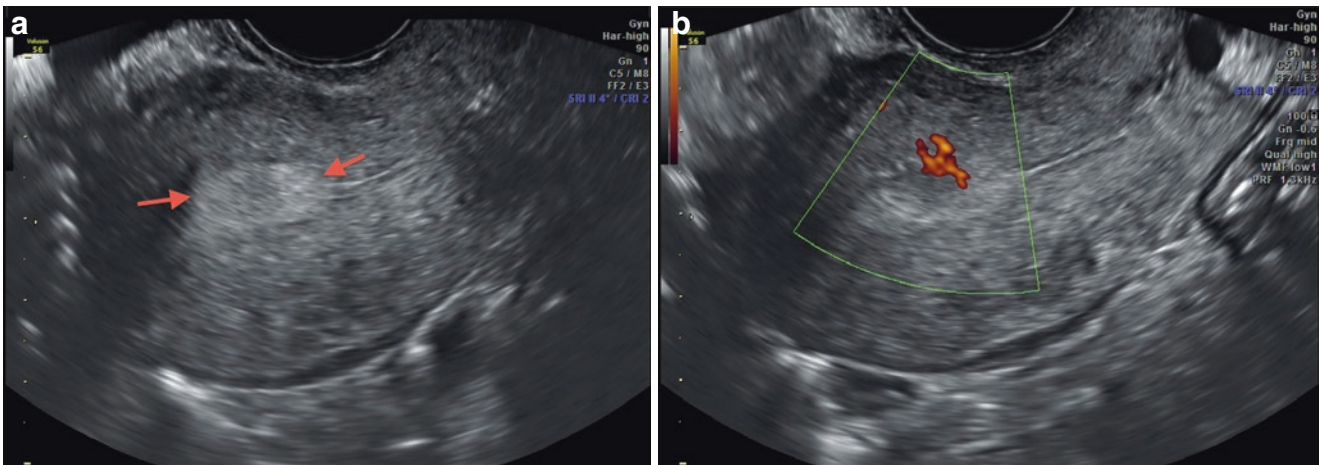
(a) Longitudinal ultrasonographic section of the uterus, showing, between the *arrows*, oval and hyperechoic focal thickening of the endometrial echo, compatible with polyp. (b) Power Doppler demonstrating vascular pedicle in the polyp
